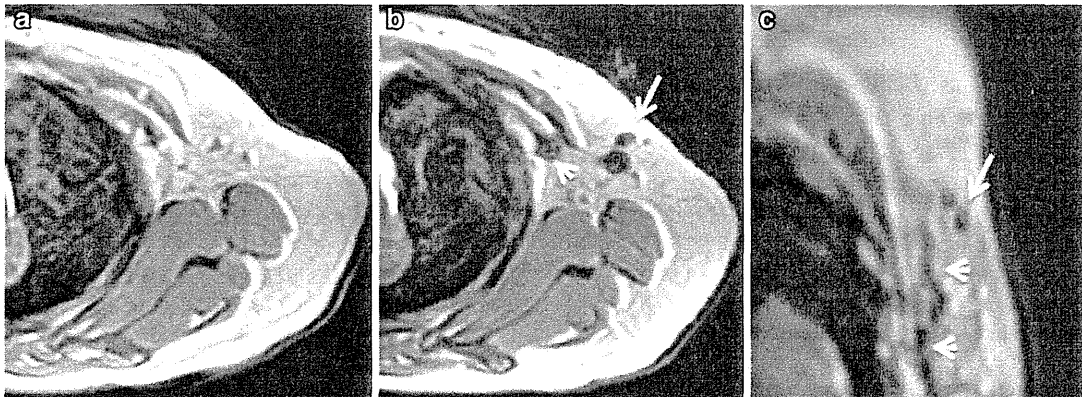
SPIO-MR lymphography in a T2*-weighted gradient echo (T2*-GRE) sequence. During the pre-injection phase in T2*-GRE, SLNs could not be delineated by MR imaging (a). Twenty minutes after injection of SPIO into the subareolar breast tissue, MR sentinel lymphography demonstrates two SPIO enhanced SLNs, one lateral to
